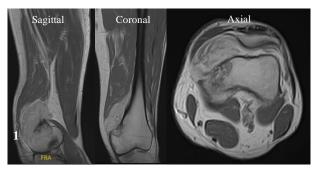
Contrasted MRI left thigh showed a contrast enhanced 2 cm x 4 cm x 8.1 cm soft tissue mass at the meta-diaphysis of the femoral anteromedial surface with bone early osteonecrosis (hypointensity).
